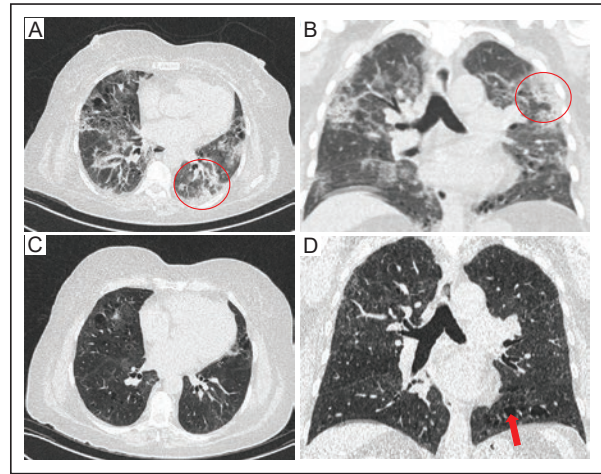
Chest CT of a 73-year-old female diagnosed with Long COVID. A: coronal and B: axial baseline images showing areas of ground-glass opacity and alveolar occupation with bilateral distribution, predominantly subpleural in the upper lobes (circle), along with areas of centrilobular emphysema in the left lower lobe. C: coronal and D: axial follow-up images, taken 19 months after the initial infection, show persistent residual ground-glass opacity with less density and centrilobular emphysema (solid arrow) without changes compared to the baseline findings.
